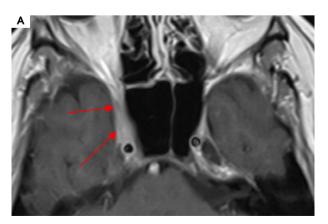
Patient number 6. Axial MRI T1 sequences with contrast showing asymmetrical reinforcement within the right cavernous sinus
